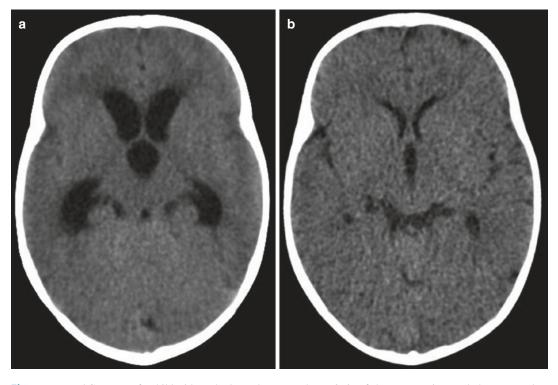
Head CT scans of a child with TB hydrocephalus before and after medical treatment: (a) the scan on the *left* shows hydrocephalus at presentation, and (b) the scan
